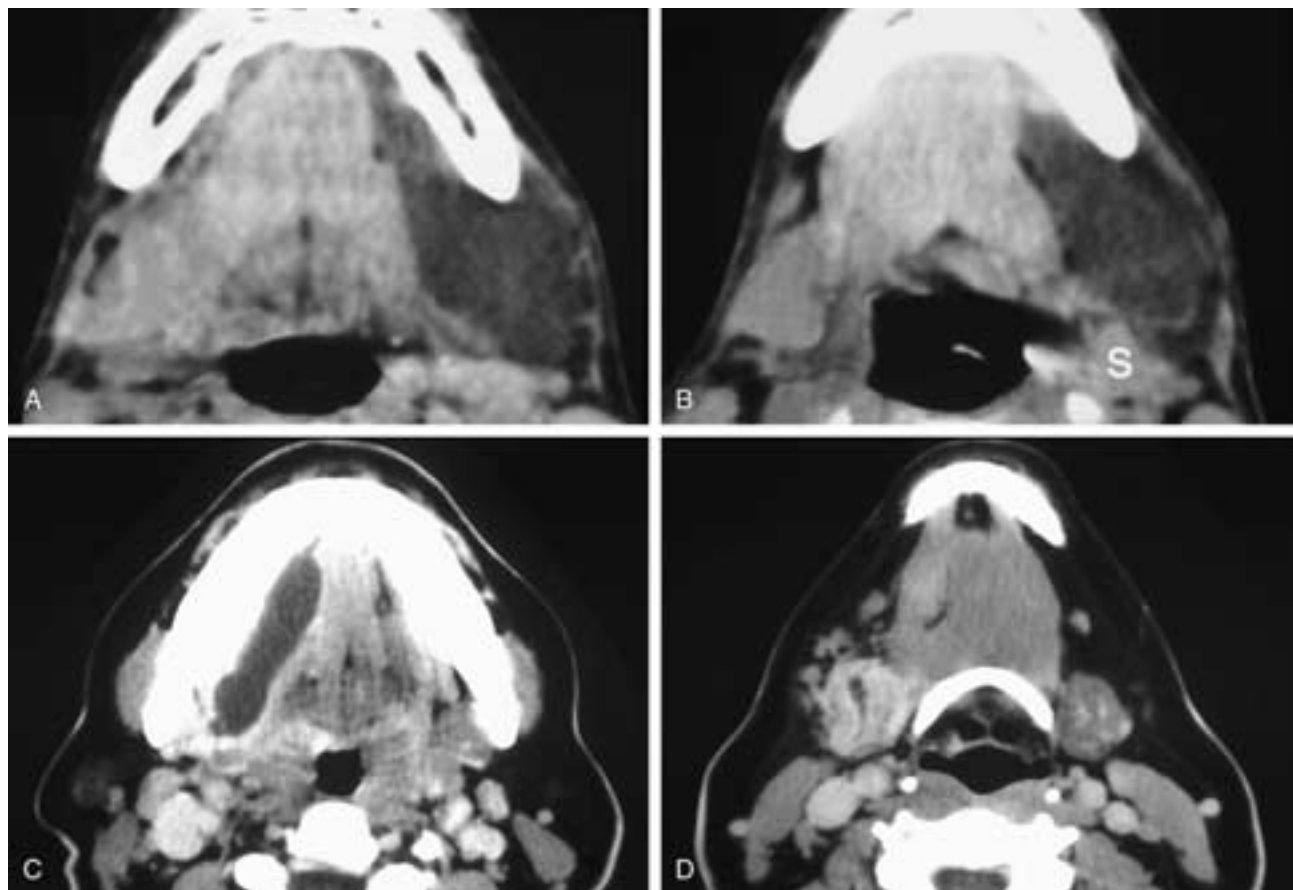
Axial CT scans through the floor of the mouth (A) and through the submandibular glands (B) show a cystic mass in the left lateral floor of the mouth that extends down into the left submandibular triangle. The left submandibular gland (*S*) is displaced backward by the cyst. This patient had a ranula. By comparison, axial contrast-enhanced CT scans through the floor of the mouth (C) and the submandibular glands (D) on another patient show a massively dilated right Wharton's duct and dilatation of the intraglandular ducts. The gland also enhances. This patient had a stricture of the opening of Wharton's duct, with dilatation of the ducts and sialadenitis.
